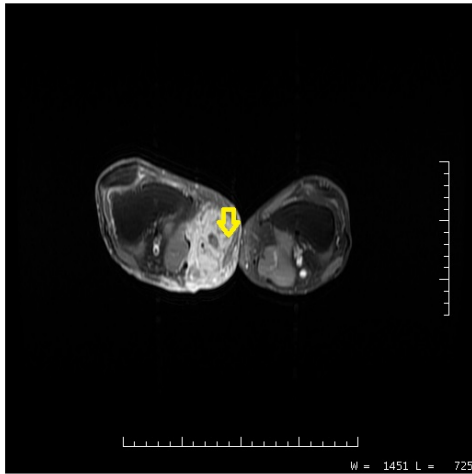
MRI scan cross sectional view showing the hyperintense soft tissue lesion.
